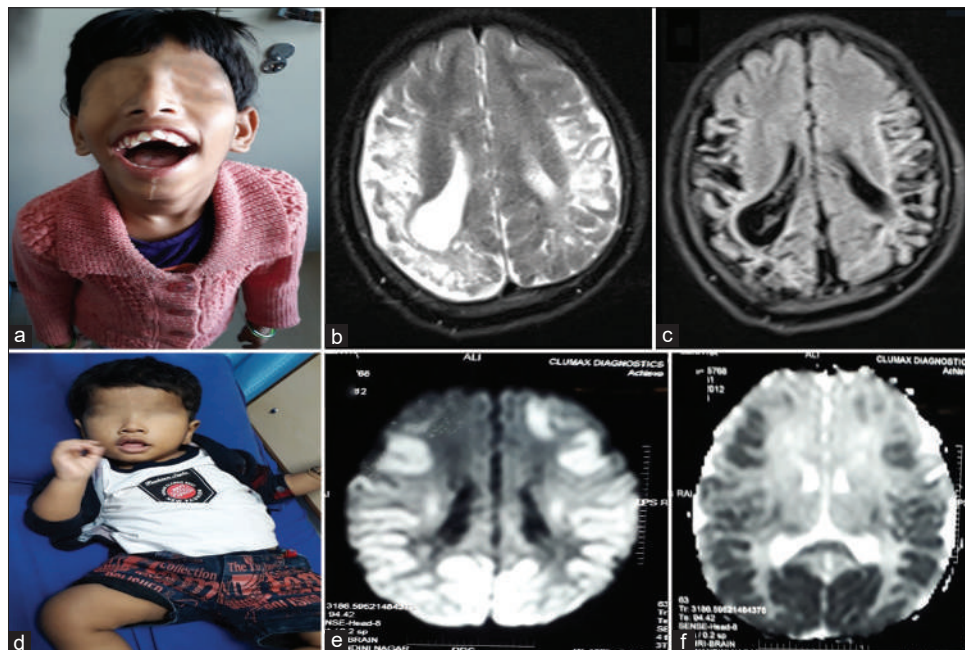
(a-c) Perisylvian syndrome – type of cerebral palsy showing drooling, magnetic resonance imaging (MRI) of brain (b and c) showing gliosis in the perisylvian region. (d-f): Neonatal hypoglycemic brain injury: Clinical photo (d) showing strabismus and MRI of brain: DWI (e) and ADC (f) showing restricted diffusion and low ADC in the bilateral parieto-occipital region.
